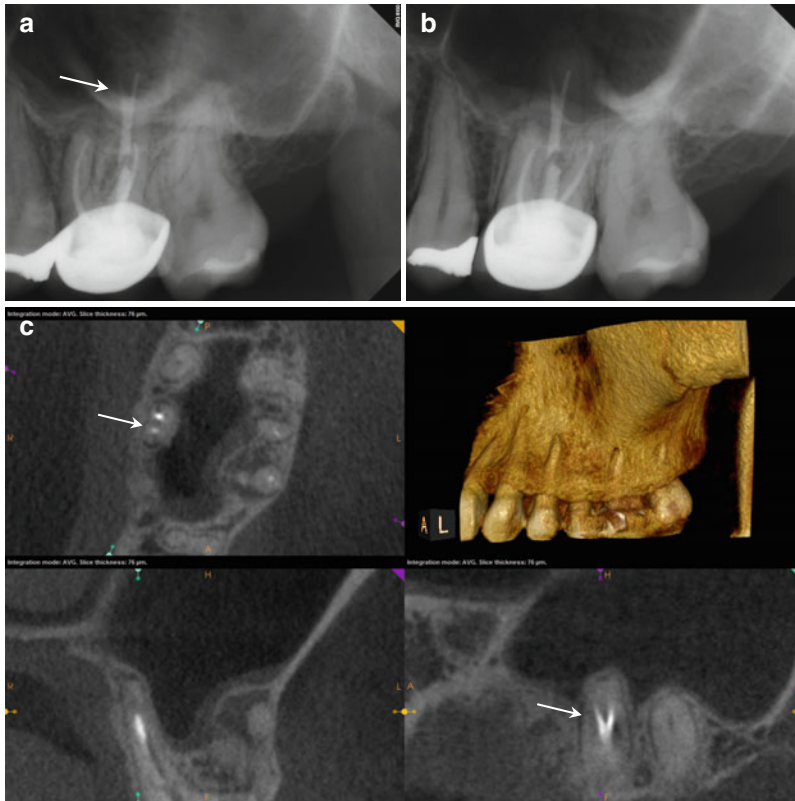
(a, b) Preoperative radiographs from different angles reveal PAP on the MB root apex, as well as the suggestion of a bifurcation of the palatal canal (*white arrow*). The distal part of the split appears more dense than the mesial, implying that the mesial radiopacity is a sealer tract. (c) The CBCT scan shows definitively two separate canals in the palatal root. Accurate measurements place the level of the bifurcation 4.3 mm from the terminus of the distopalatal canal. The higher density spot in the axial and sagittal sections of the palatal root is the gutta-percha; the lower density object is the sealer tract (*white arrows*). (d) This colored sagittal section has been magnified to ascertain the angle of the bifurcation; the deviation is less than 40° , so an appropriately angled instrument should be able to engage the orifice without difficulty (*white arrow*). When the angle of bifurcation is 60° or more, the dilaceration may be too abrupt to allow easy insertion of the file without additional coronal modification of the common canal space. (e) The axial section of the MB root demonstrates the eccentric placement of the MB root canal filling, indicative of the presence of an MB₂ canal (*white arrow*). The coronal view of the same root suggests that the MB₂ may, in fact, be a separate root fused to the MB₁ (*red arrow*). (f) The colored coronal section highlights the MB₂ root and the distension/expansion of the floor of the maxillary sinus from the developing apical lesion (*yellow arrows*). (g, h) Final treatment radiographs presenting the obturation of the separate MB1/MB2 canals as well as the mesiopalatal and distopalatal canals. (i) 12-month recall radiograph: the lesion at the MB root appears healed, and the patient is asymptomatic
